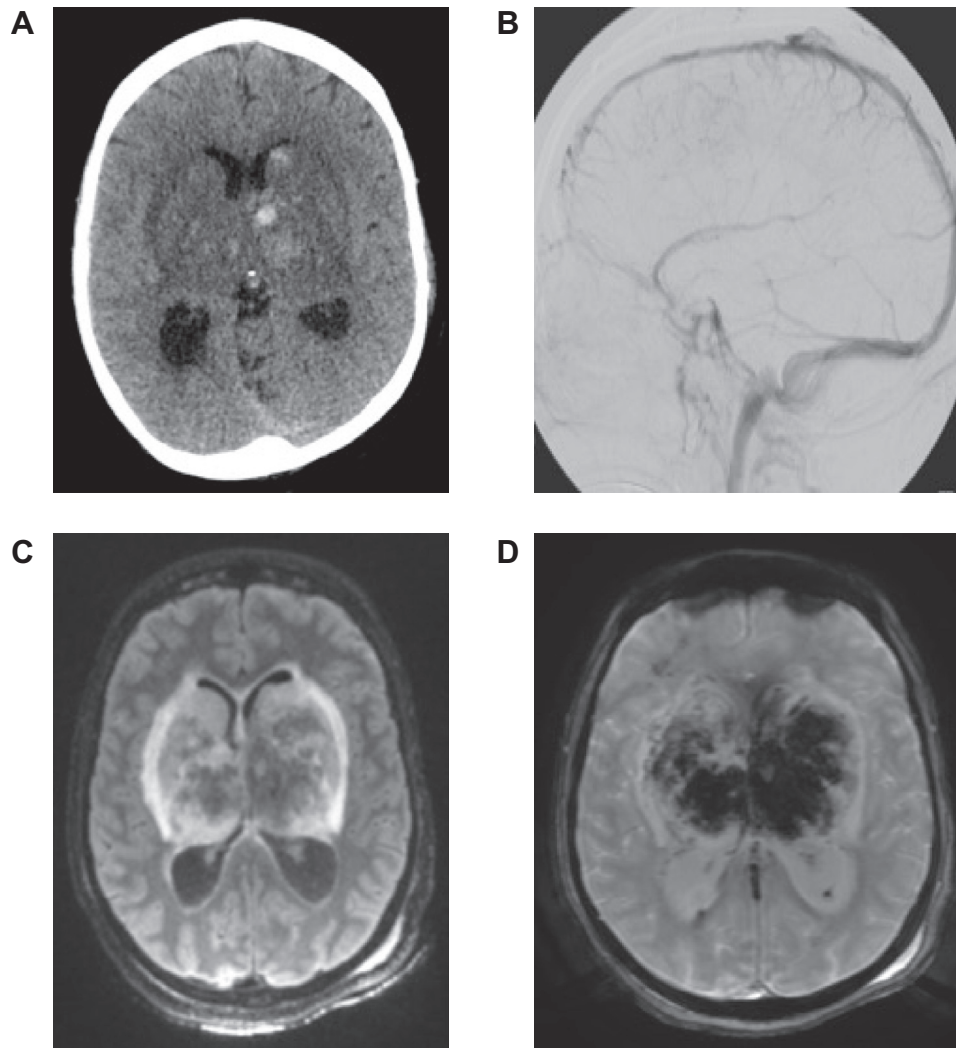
A. Head CT showing hemorrhagic infarct of the basal ganglia and bilateral thalami. B. Angiogram showing absence of the straight sinus, inferior sagittal sinus, vein of Galen and internal cerebral veins. C. Axial T2-Flair MRI showing a mixture of cytotoxic and vasogenic edema and D. Axial SWI MRI showing extensive susceptibility involving the bilateral deep gray structures.
